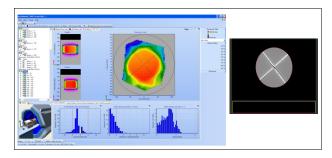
Measurement compared to calculations for the CT Model. Scan of DELTA4 with the CT table del (bright lines repre ritten in TPS) sent the detector planes, density ove
